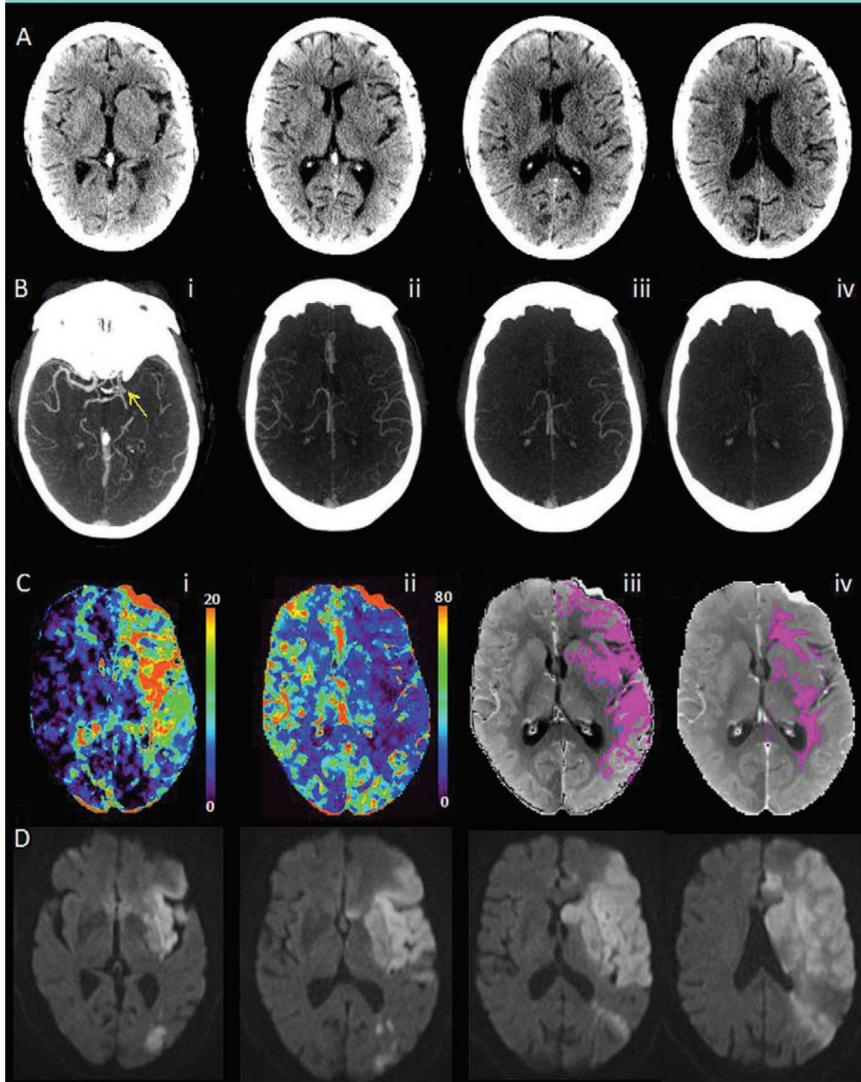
Multimodal CT images obtained 2 hours 18 minutes after symptom onset in an 87-year-old woman with an NIHSS of 15 and left hemisphere symptoms. *A*, Unenhanced CT ASPECTS score was 6. *B*, A proximal left M1 MCA occlusion (*i*). Multiphase CT angiography (three phases) maximum intensity projection images (*ii*, *iii*, *iv*) are indicative of one phase delay at worst, with similar extent and prominence when compared with the contralateral side. These indicate of a score of 4 and suggest the patient should undergo treatment. *C*, CT perfusion Tmax and CBF maps (*i*, *ii*). A CBF-defined infarct core is 1 mL (*iii*, no blue regions). A mismatch ratio of 106 and a small infarct core suggests the patient should undergo treatment. Multiphase CT angiography and perfusion CT imaging are congruent for treatment decision. *D*, MR diffusion images at 26 hours after admission show the final infarct as hyperintense. This patient did not attain recanalization with endovascular therapy.
